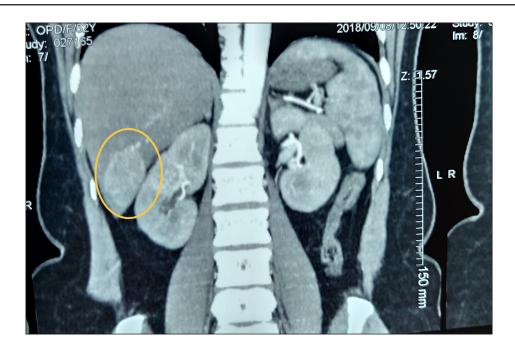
CT image of the liver lesion
